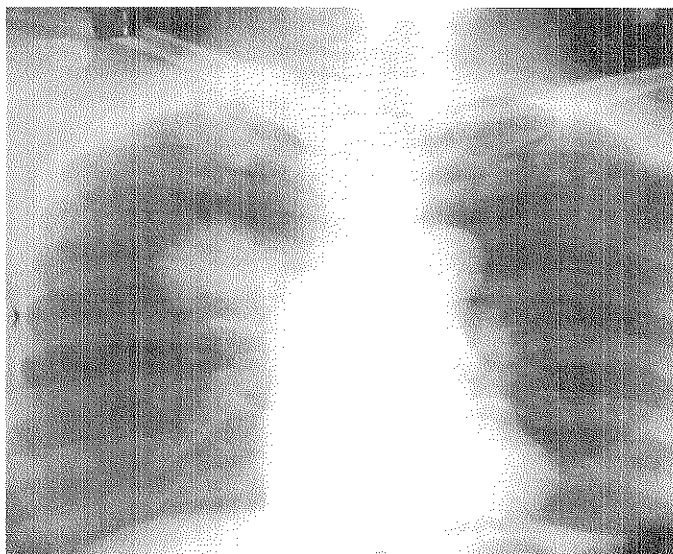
PA View Chest X-Ray showing a radio-opaque lesion on right upper lobe of lung.
